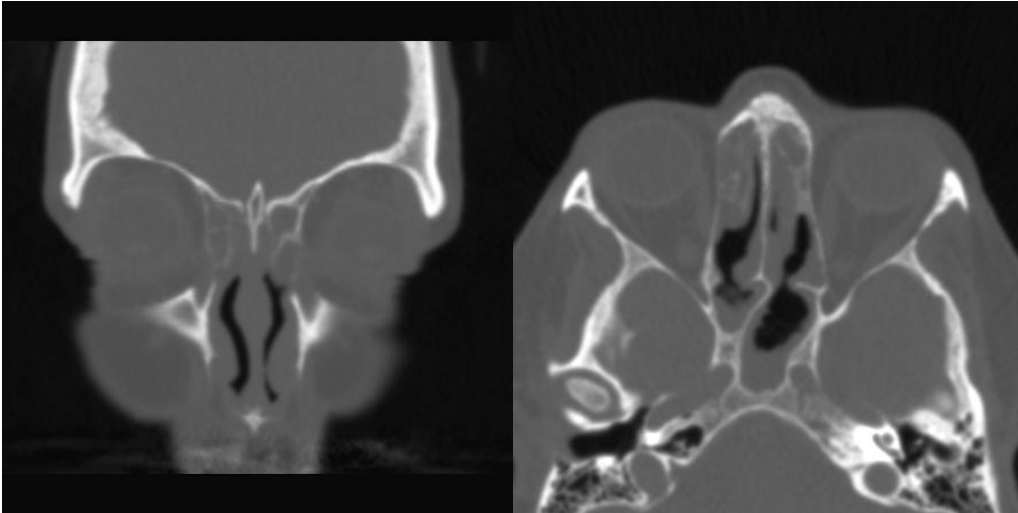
These CT images (coronal on left; axial on right) are of a patient who has had prior sinus surgery and had ethmoid cells left behind. These ethmoid cells have become diseased and will require revision surgery for correction.
